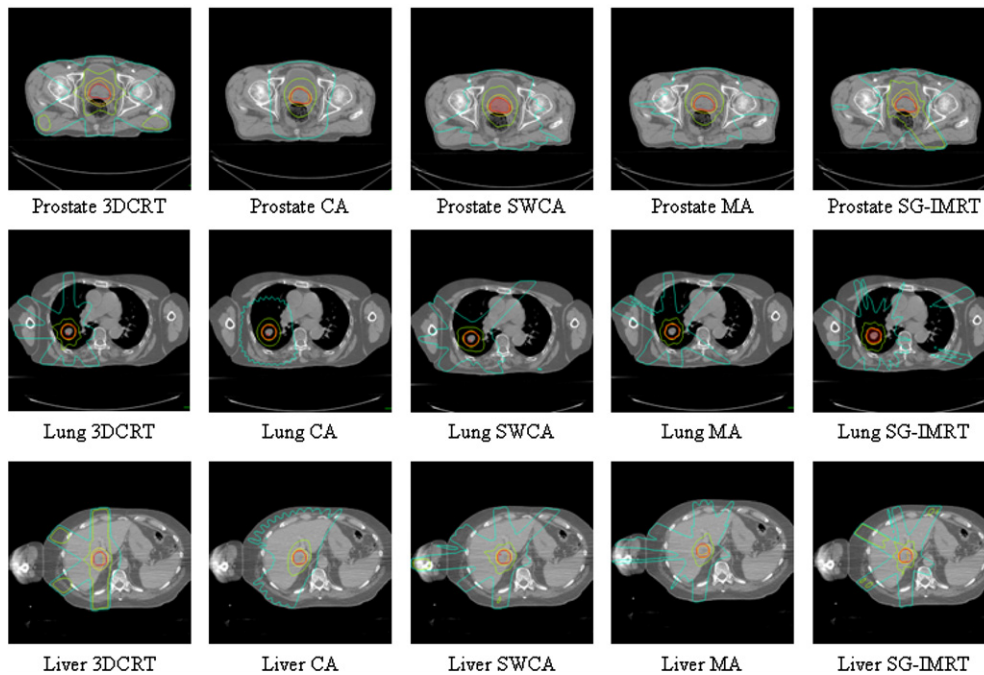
Isodose distributions from the same CT slice for the prostate (2.5 Gy per fraction), lung and liver cases. The PTV is shown in red. The orange isodose distribution shows the prescription line (70 Gy for prostate, 60 Gy for lung and 36 Gy for liver); the yellow, green and blue lines show the 90%, 50% and 20% prescription isodose, respectively.
